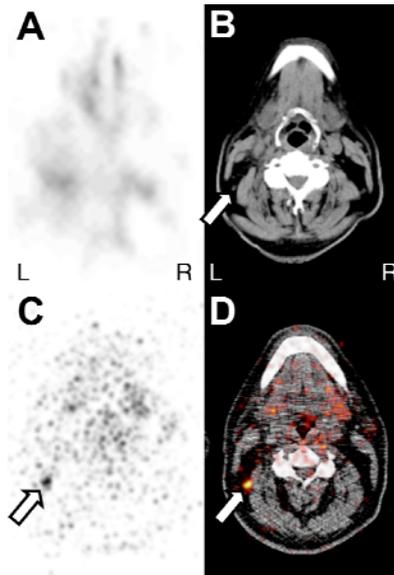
Patient with an iodine-positive metastasis (no. 1), which was only detected by early ^{124}I PET/CT (C: axial cervical PET, D: corresponding fused PET/CT) but not discernible by ^{131}I SPECT/CT (A: axial cervical SPECT corresponding to C, B: corresponding SPECT/CT). The white arrows mark the lymph node metastasis right nuchal.
